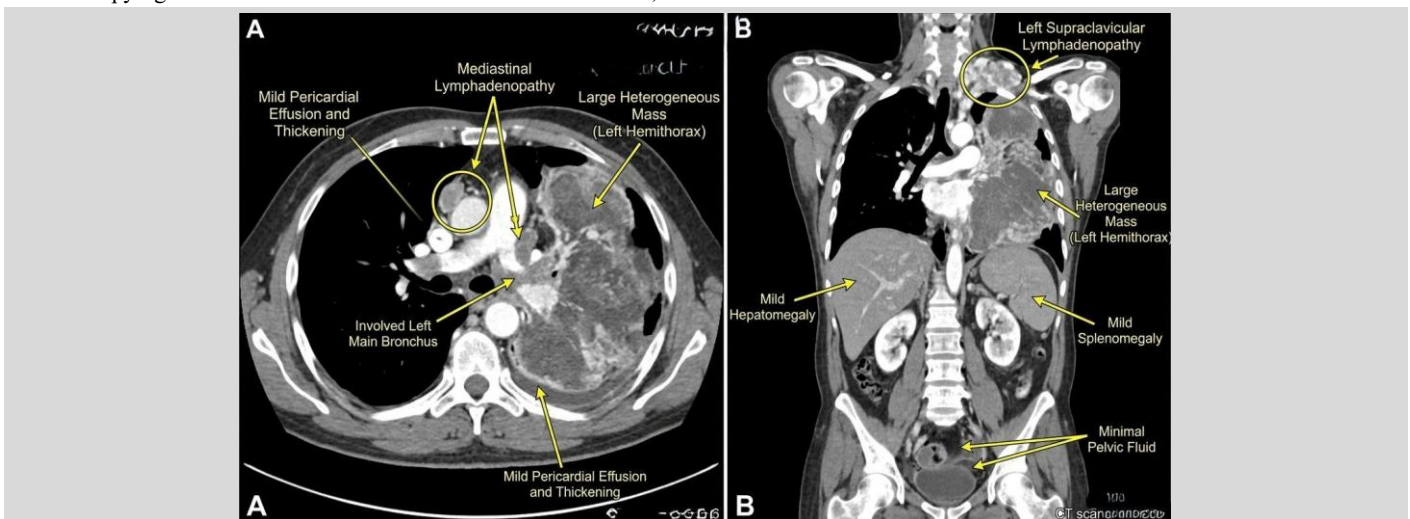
Contrast-enhanced computed tomography of the chest, abdomen, and pelvis demonstrates a massive, multilobulated, heterogeneously enhancing soft-tissue mass occupying the entire left hemithorax, with internal low-attenuation areas suggestive of necrosis or hemorrhage, indicative of aggressive tumor biology. The lesion shows direct encasement and luminal narrowing of the left main bronchus (as marked), favoring true airway invasion. There is extensive mediastinal and left supraclavicular lymphadenopathy, consistent with advanced nodal dissemination. Mild pericardial effusion with associated thickening suggests early serosal involvement. Abdominal findings include mild hepatomegaly and splenomegaly (highlighted), likely reflecting systemic or reticuloendothelial response in the absence of focal lesions, along with minimal pelvic free fluid. The contralateral lung remains free of metastasis.
